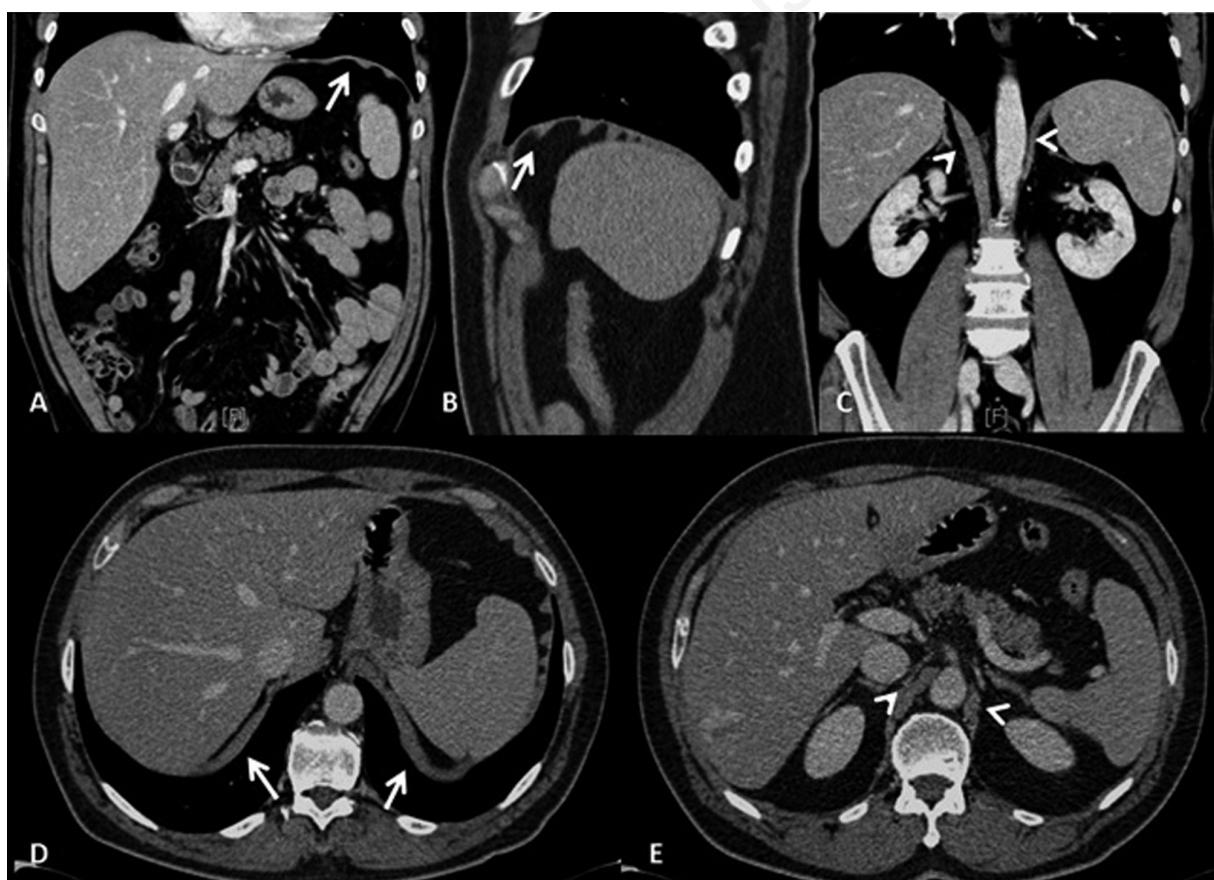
Computed tomography (CT). The CT images in the coronal and axial plane allow the visualization of the diaphragm as a hyperdense linear band interposed between the chest and the abdominal cavity (respectively A and D, see arrows). Sagittal images highlight a sort of "corrugated" morphology that shows the orientation of the muscle bundles (B, see arrows), which may appear more or less pronounced in wellness or pathological conditions, such as chronic obstructive pulmonary disease. Clearly visible also appear diaphragmatic pillars both the coronal plane (C) that the axial plane (E) (arrow heads).
